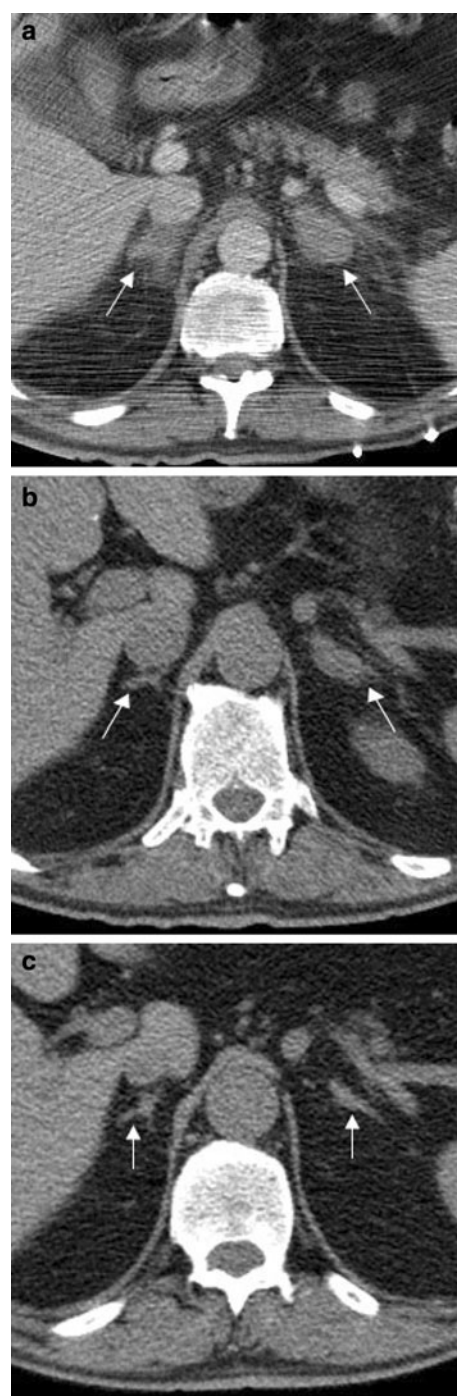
Three consecutive CT scans at the level of the adrenal glands (white arrows). a The initial contrast-enhanced CT scan, demonstrates bilateral adrenal enlargement. There is retroperitoneal fatstranding adjacent to the adrenal glands. b A follow-up non-enhanced CT at a 1-month interval, demonstrated residual enlargement of the left adrenal gland with minimal retroperitoneal fatstranding. The right adrenal gland size was normalised. c At 3-month follow-up from the initial CT, the non-enhanced CT showed normal sized adrenal glands. There is no residual retroperitoneal fatstranding, or signs of adrenal calcification or cystic changes
